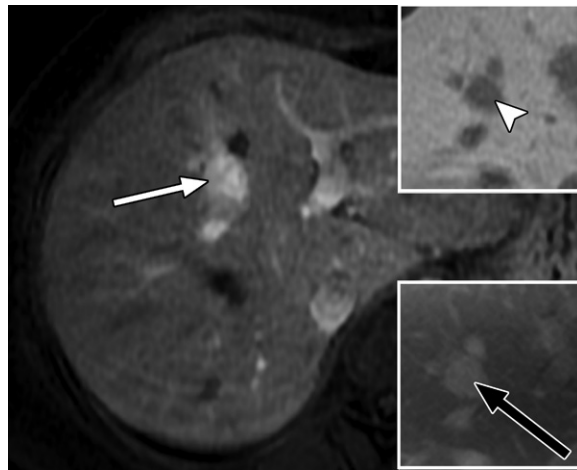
Contrast enhancement of a hemangioma with gadoxetate and an extracellular contrast agent in a 33-year-old woman. Axial T1-weighted arterial phase MR image shows hyperenhancement (white arrow) of a segment VIII liver lesion similar to that of the venous blood pool. With gadoxetate, the transitional phase image obtained 5 minutes after contrast agent administration (top right inset) shows hypoenhancement of the lesion (arrowhead). MR image from a repeat examination with an extracellular agent (bottom right inset) shows persistent enhancement at 5 minutes after contrast agent administration similar to that of the venous blood pool, confirming the diagnosis of a flash-filling hepatic hemangioma.
